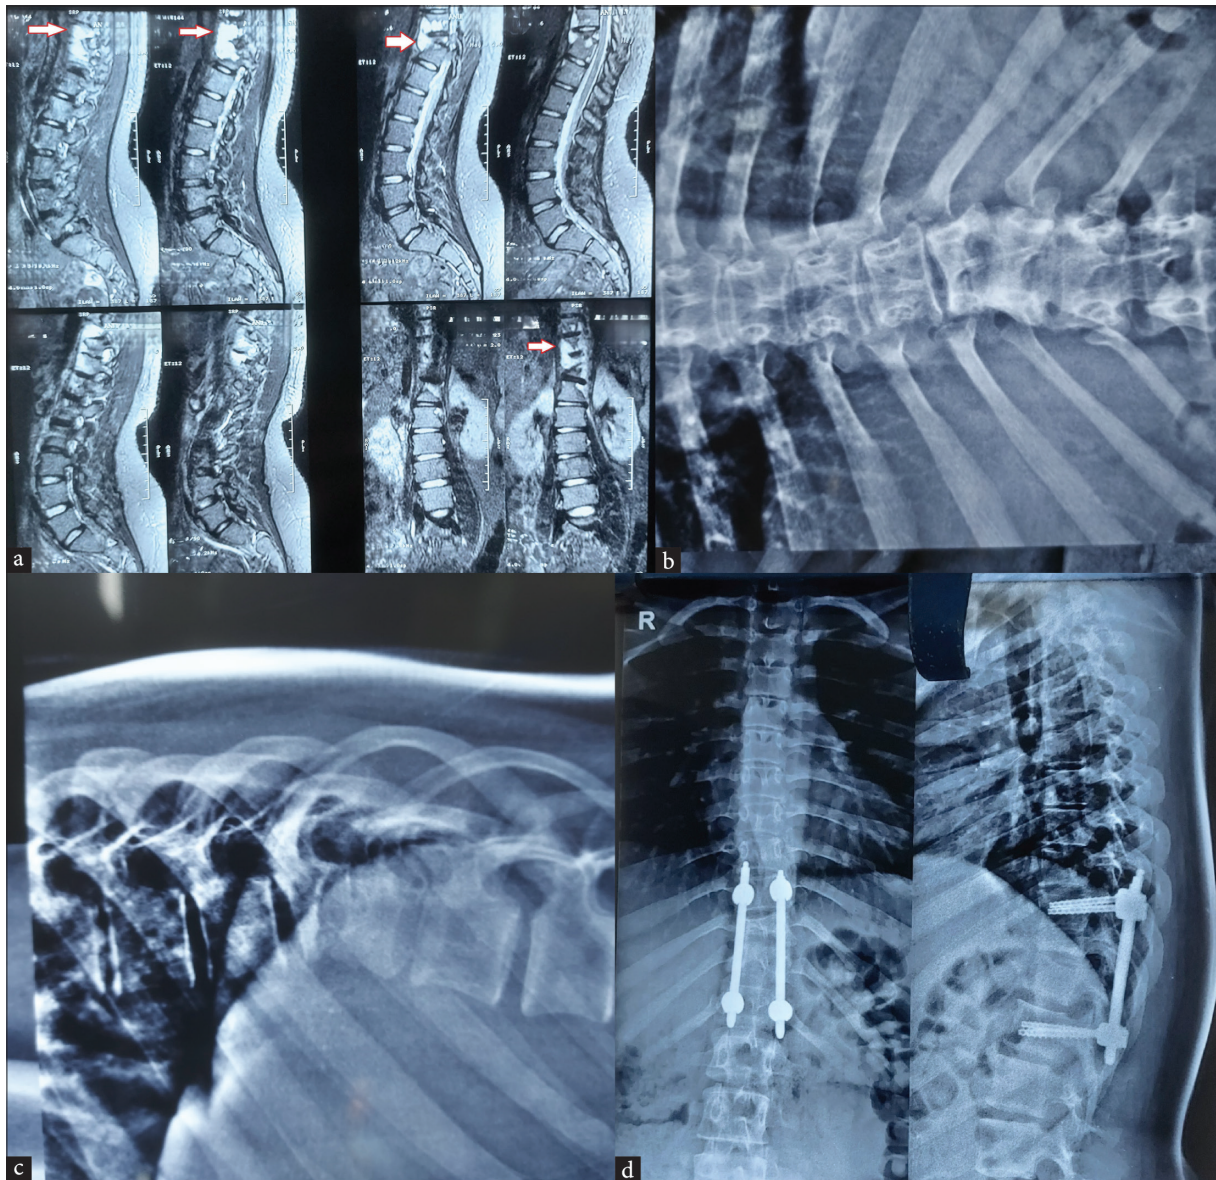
(a) Pre-op MRI of a patient with a thoracic wet lesion arrows showing wet lesion (abscess). (b) Pre-op x-ray AP view of the same patient. (c) Pre-op x-ray LAT view of the same patient. (d) Post-op x-ray AP and lateral view of the same patient. MRI: Magnetic resonance imaging, AP: Antero posterior, LAT: Lateral.
